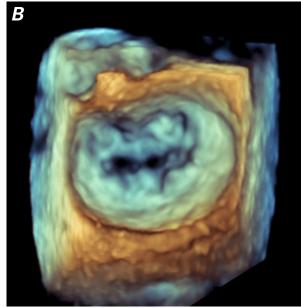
Transesophageal echocardiograms on day 8 show A) severe mitral regurgitation with an eccentric jet (midesophageal 4-chamber view) and B) malcoaptation of the mitral leaflets during systole (3-dimensional view).
